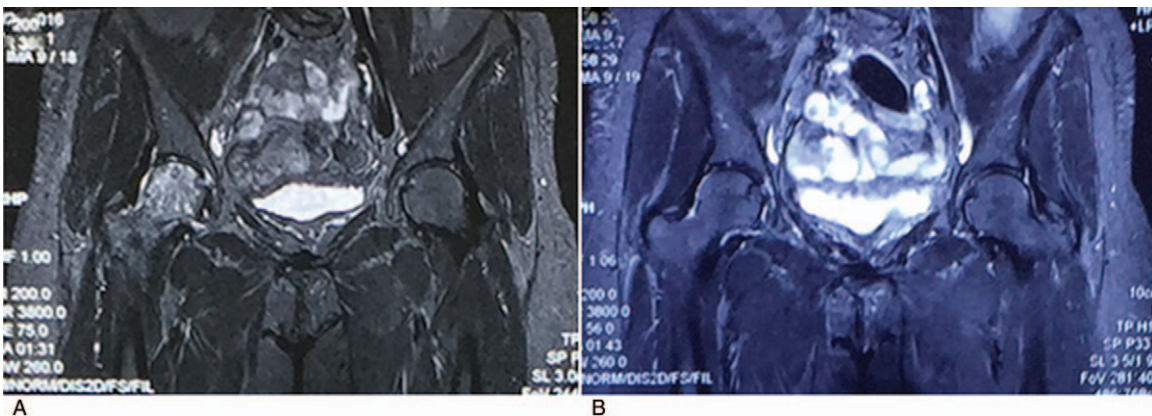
(A) Preoperative magnetic resonance imaging examination showed necrotic area >50%. (B) Post-operation with Tongluo Shenggu decoction, 9 months' follow-up showed significantly decreased necrotic area, new bone formation, and no occurrence of femoral head collapse.
